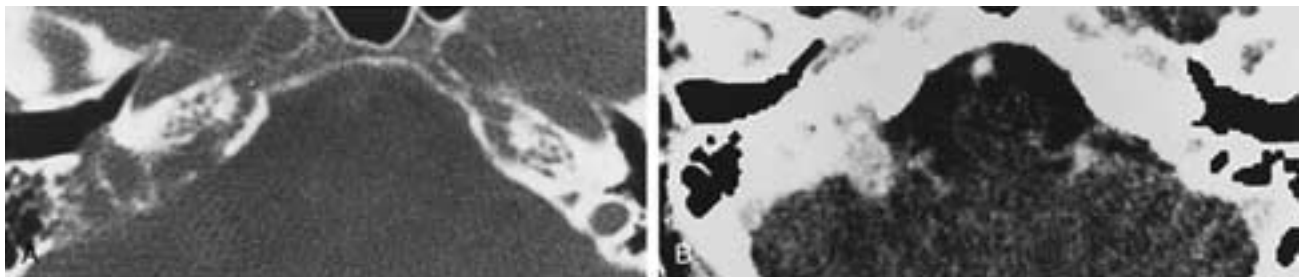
Medium-sized glomus jugulare tumor. A and B, Axial bone algorithm and soft tissue algorithm postcontrast CT. Fisch type D tumor with small intracranial extension. For resection, a combined otologic and neurosurgical approach is required.
